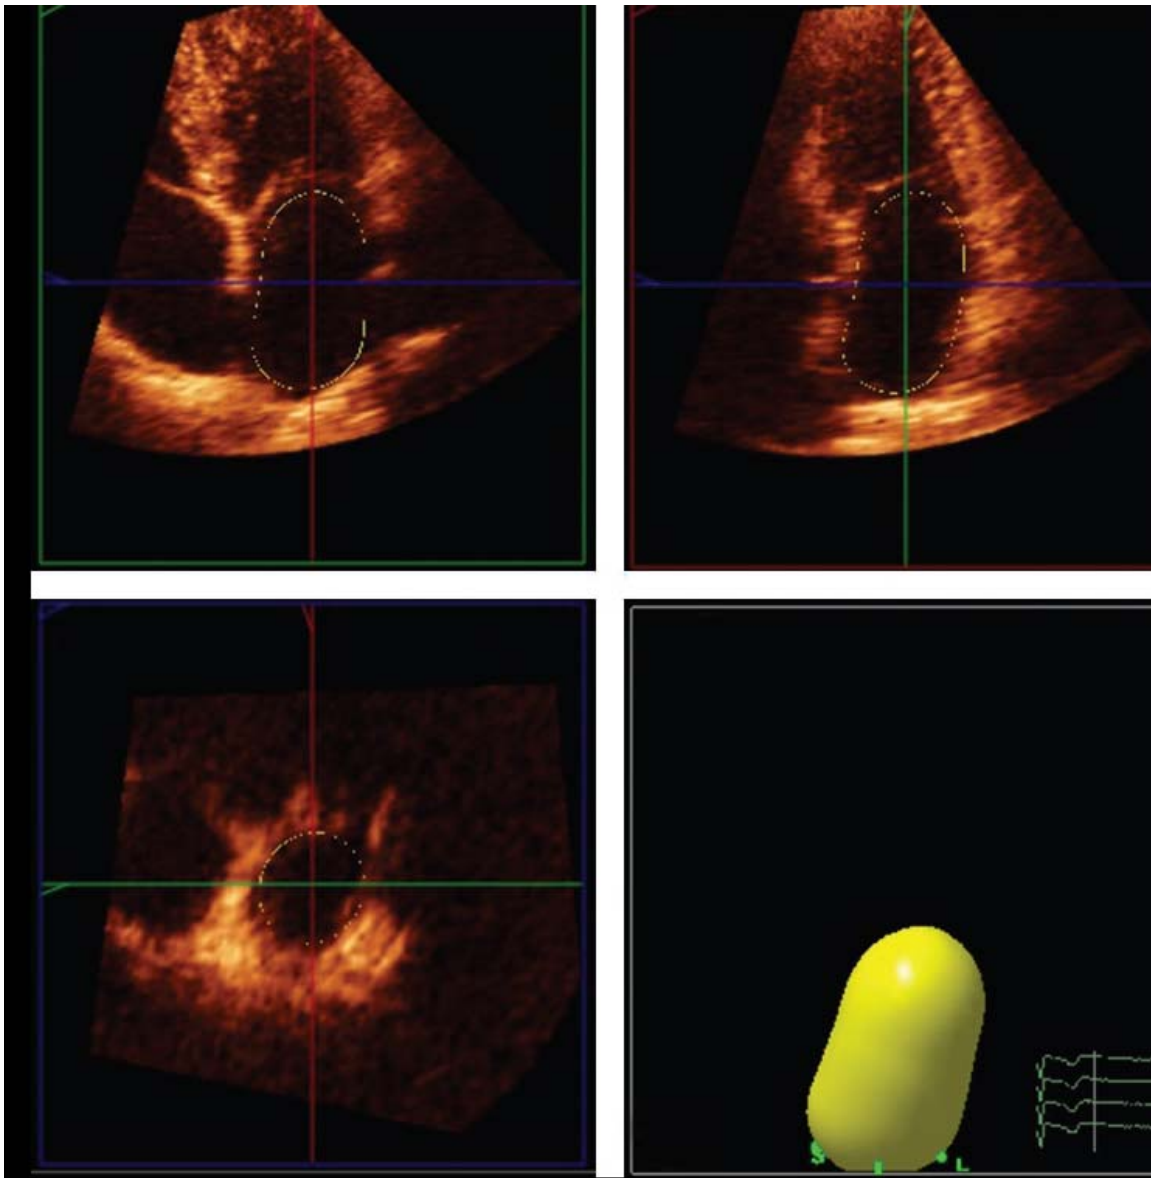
Real-time three-dimensional echocardiogram for the assessment of Left Atrial volumes. Panels A to C represent the coronal, sagittal and transverse planes, respectively. With the use of a five-point tracing algorithm, Left Atrial volumes can be obtained throughout the cardiac cycle, represented by the “shell” in panel D. In this example, Left Atrial maximum volume was 53 ml
